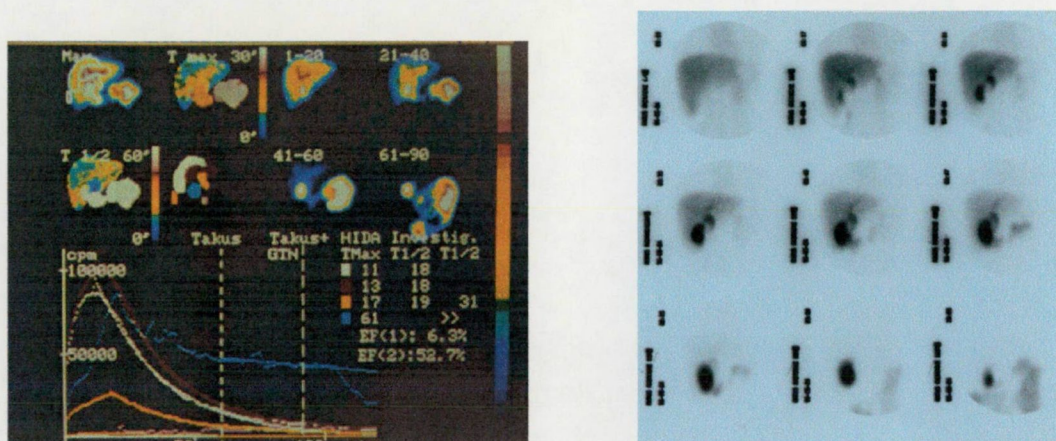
Representative hepatobiliary scintigraphy (TACs on the left and analogue pictures on the right) on an ABP patient with an obvious improvement of the GB contraction due to GTN and CCK₁₀ coadministration as compared to CCK₁₀ alone.
